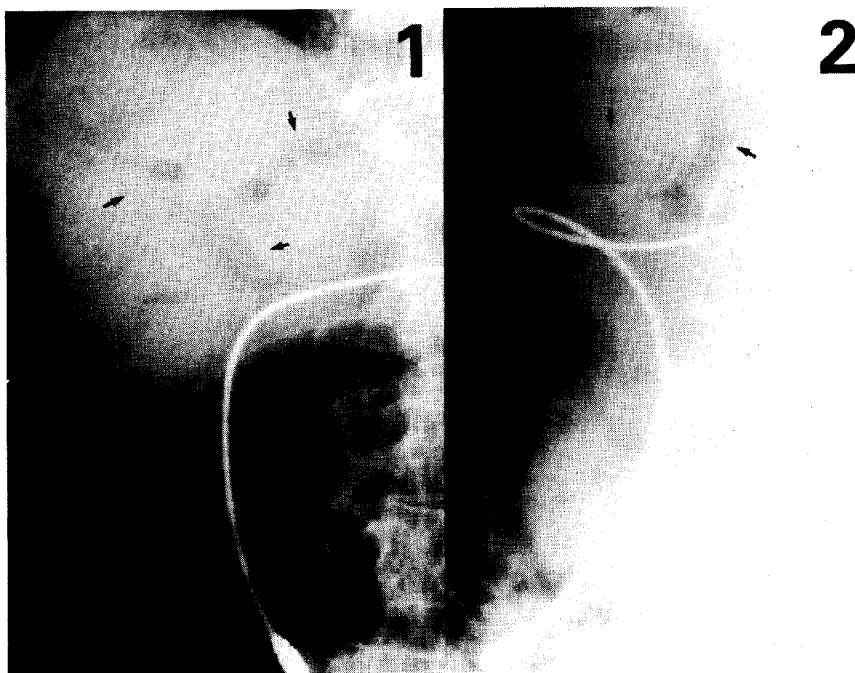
Roentgenogram of the abdomen. Air-filled, branching structures (arrows) in the area corresponding to the liver under the right diaphragm. 1. Postero-anterior view in the standing position. 2. The 1st oblique position. Duodenal tubing for feeding barium into the duodenum can be seen.
